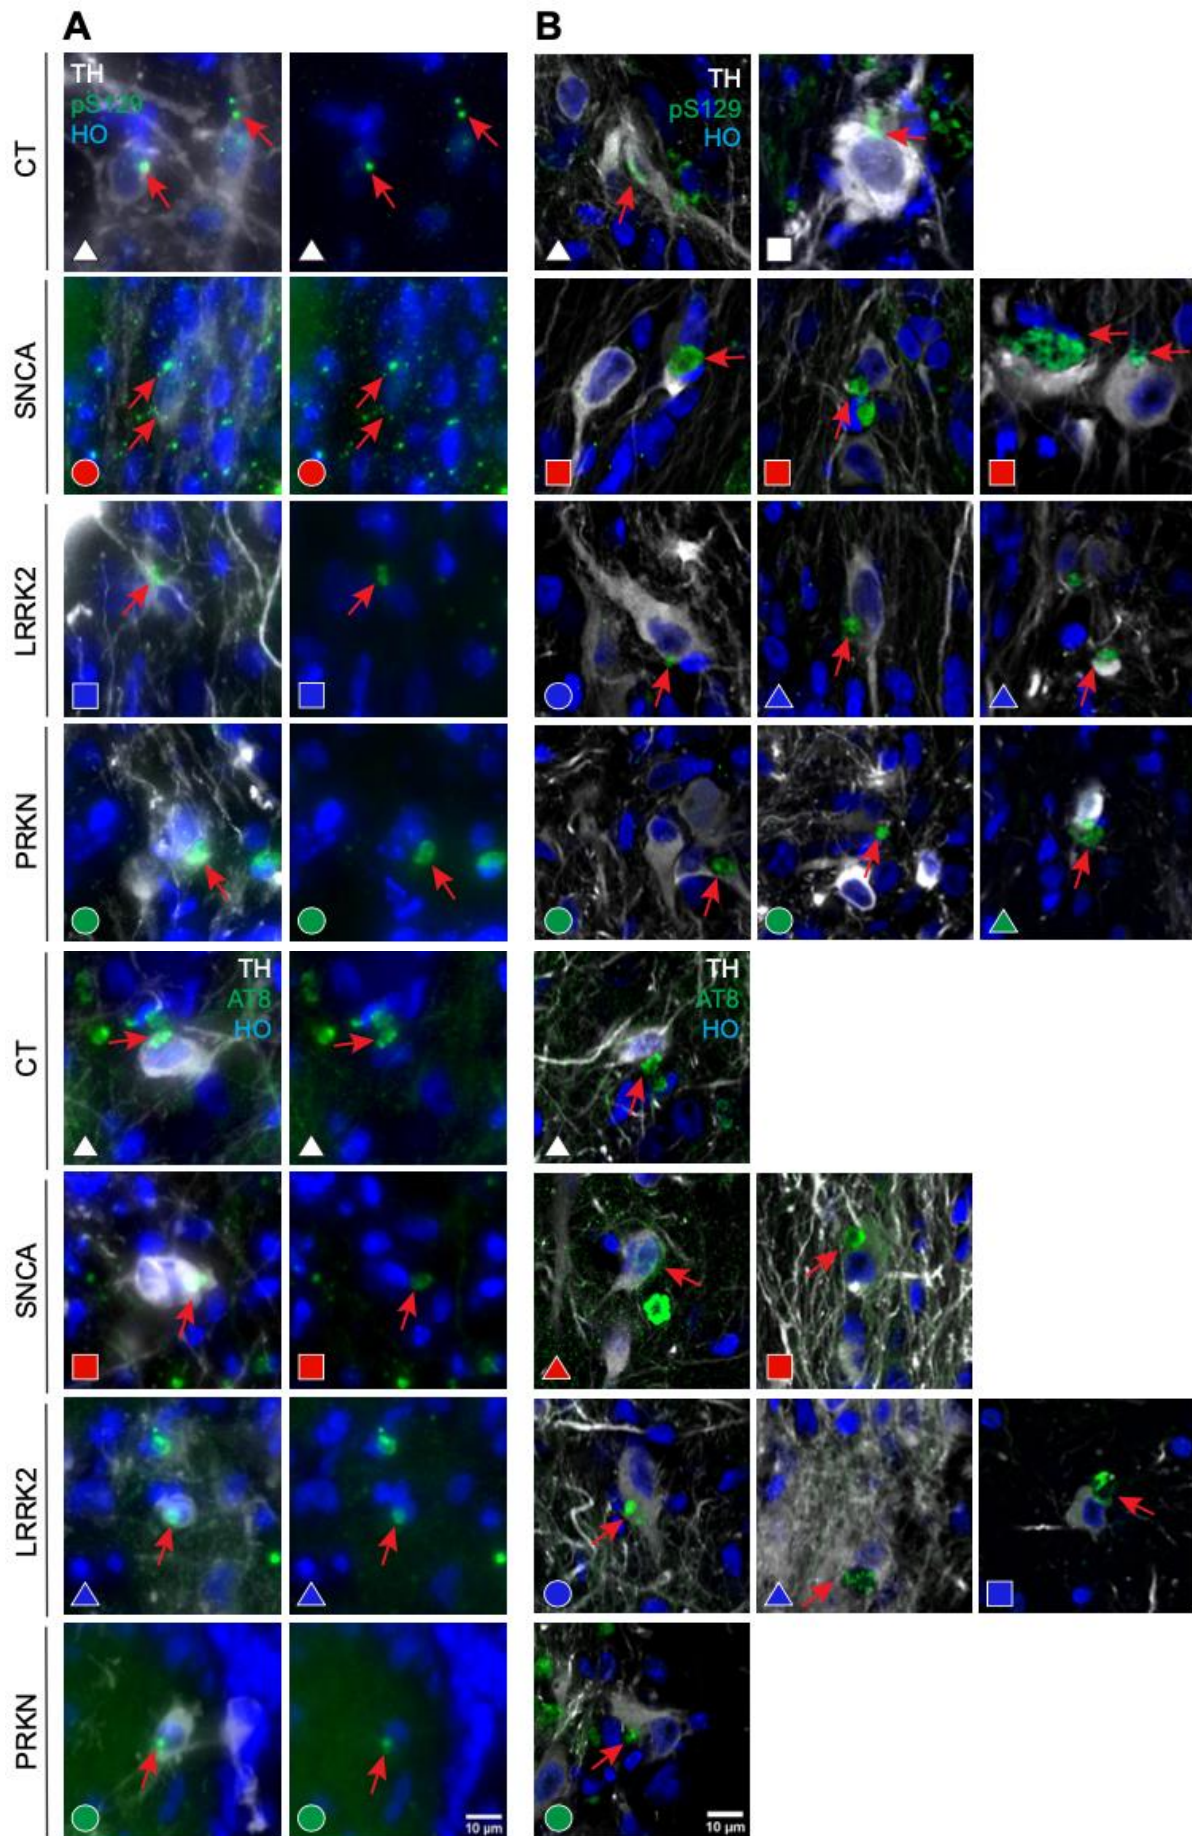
Phospho- α -syn and tau aggregate-like structures in control (CT) and *SNCA*, *LRRK2* and *PRKN*
